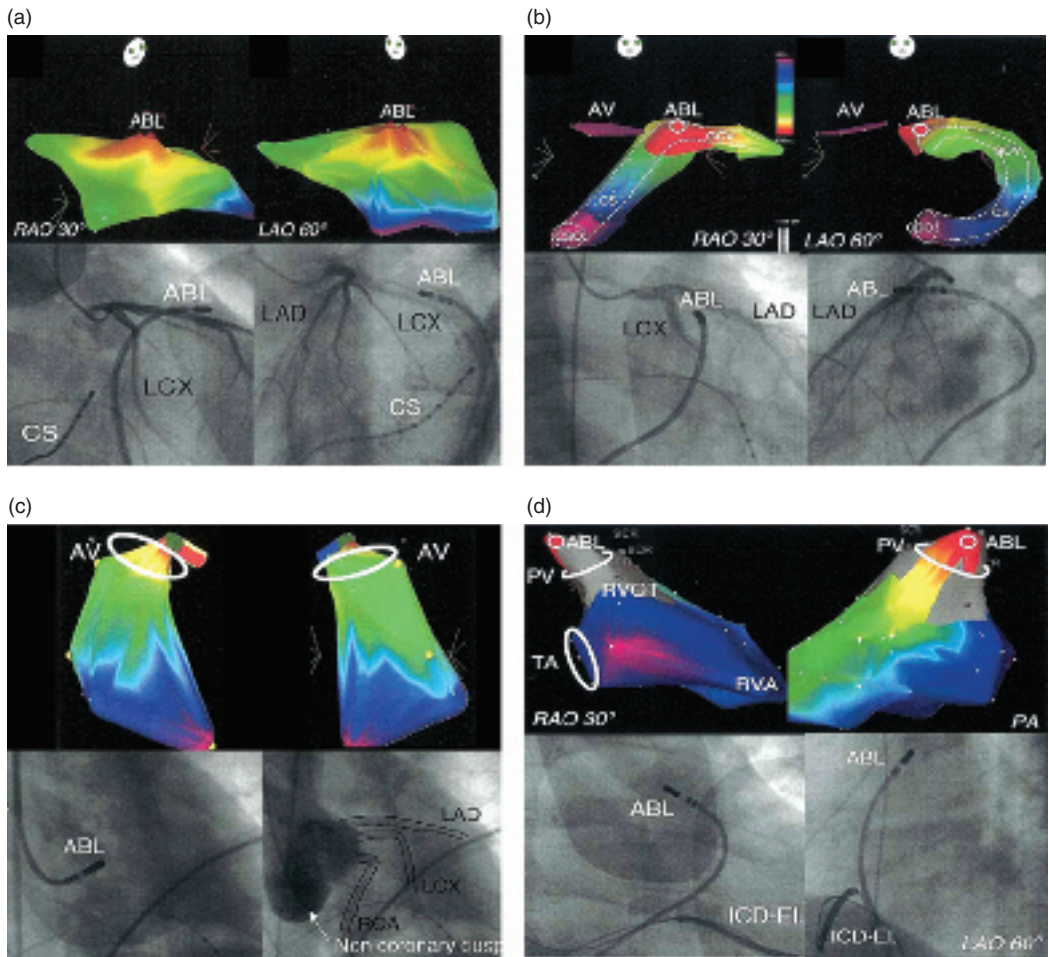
Idiopathic epicardial left ventricular outflow tract tachycardia. (a) Ablation of idiopathic VT from the epicardium through a percutaneous pericardial access. Epicardial electroanatomic activation maps during VT. Ablation (dark red dots) at the earliest activation site (red color) was successful. Radiographs show the ablation site in relation to the left coronary artery. (b) Successful ablation of idiopathic VT from the great cardiac vein (GCV) via the coronary sinus (CS). CS electroanatomic activation maps during idiopathic VT. Radiographs show the ablation site. (c) Left ventricular outflow tract electroanatomic activation maps including the aortic sinus of Valsalva during idiopathic VT. Radiographs show the ablation
